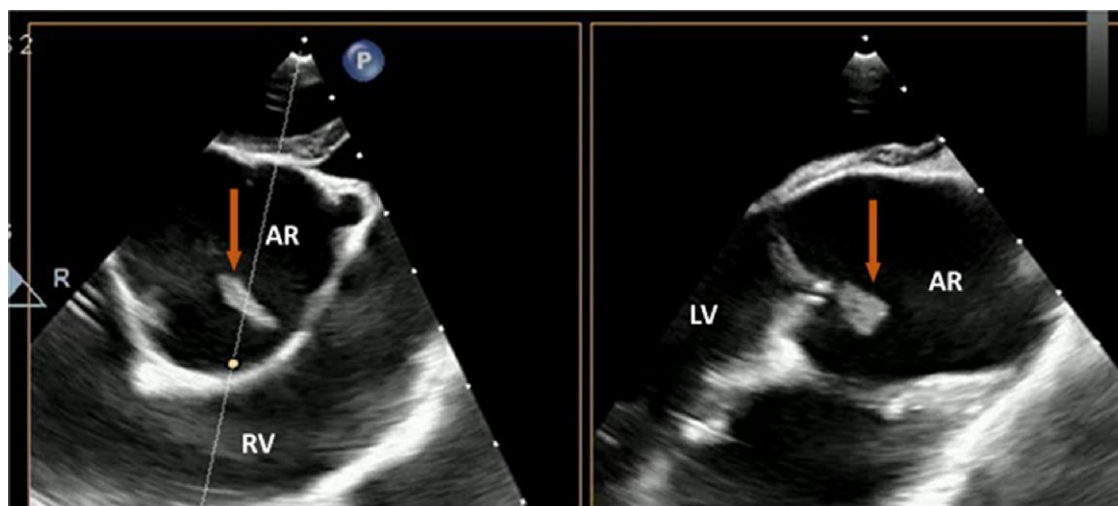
Transoesophageal echocardiogram. Nodular pedunculated mass dependent on the right coronary sigmoid valve leaflet (arrow). LV, left ventricle; RV, right ventricle; AR, aortic artery.
